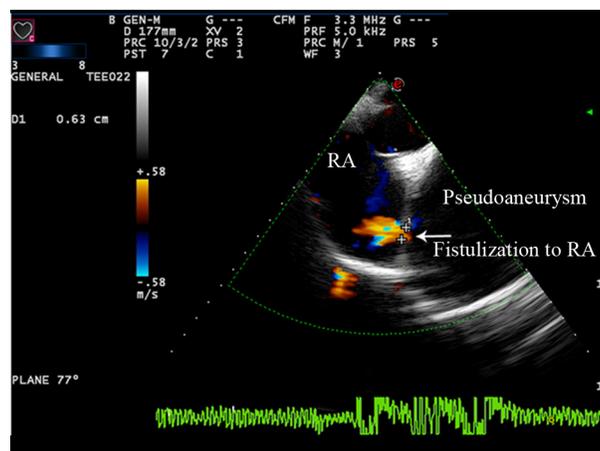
Intraoperative echocardiography before surgical repair: the off-axis view of transesophageal echocardiography demonstrates the color flow of the pseudoaneurysm fistulizing to the right atrium with a continuous flow via a small orifice, estimated to about 6mm in size (arrow)
